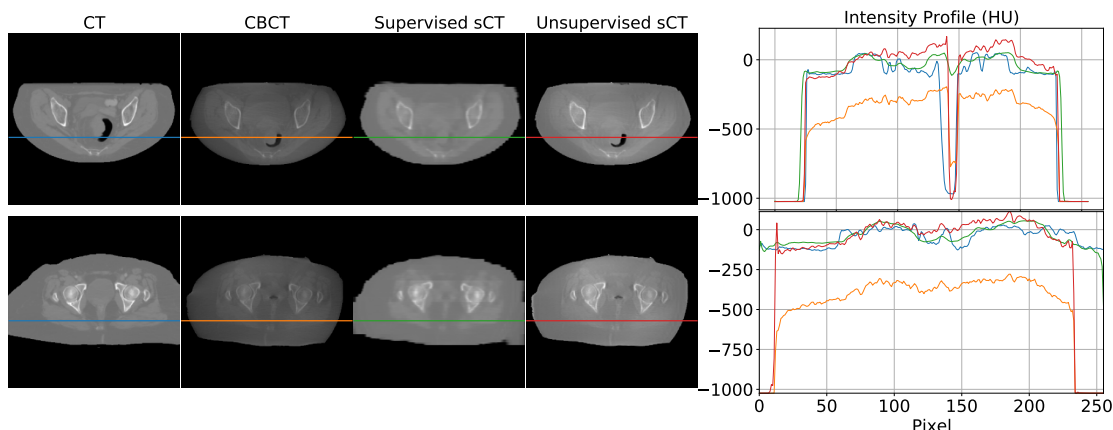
Examples of non-linearity of CBCT scans. Air gap introduced a notch in the intensity profile (*top*). Beam hardening is visible as a convex shape in the orange curve of both examples (*bottom*). Images are displayed with Window = 2000, Level = 0.
